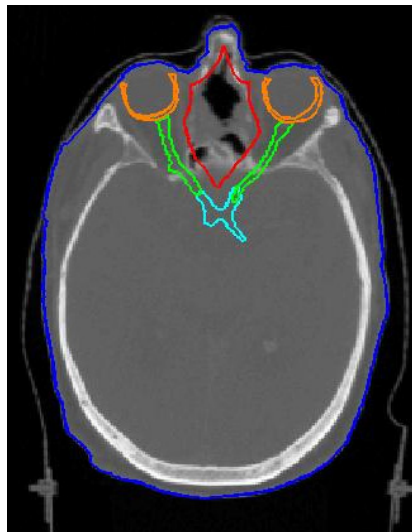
Transversal CT image of an ethmoid sinus cancer patient. The anatomical contours of the PTV (red), skin (blue), retinas (orange), optic nerves (green) and optic chiasm (cyan) are shown. The PTV contains a significant amount of air.
